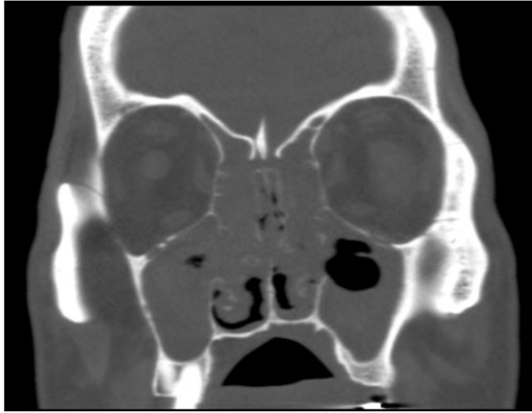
CT sinus without contrast from day 6 revealing pansinusitis without evidence of bony erosion.
